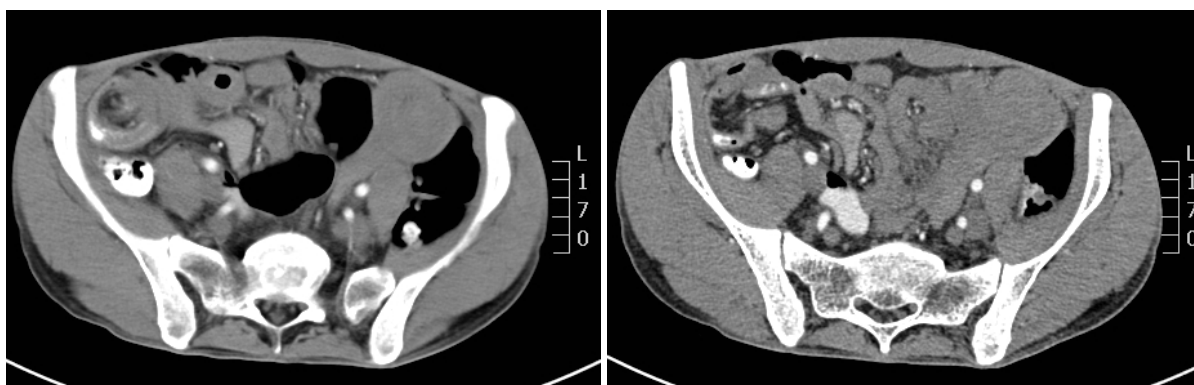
Abdominal and pelvic CT scan. It showed that many polyps are distributed in the descending duodenum and the small intestine, and the local intestinal canal was torsional.
